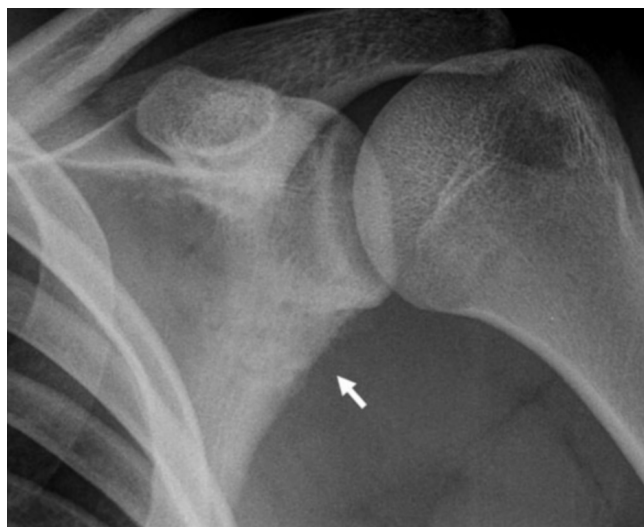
17-year-old male with scapular stress fracture. Radiograph of the shoulder shows lesion in the scapula with aggressive features including lysis of the inferior border of the body of the scapula and adjacent new bone formation (arrow).
